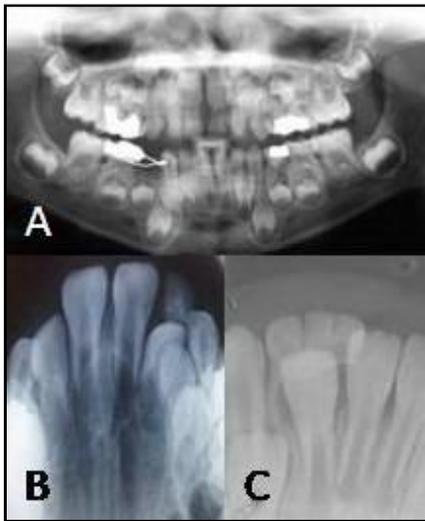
Panoramic and periapical view of supernumerary teeth
